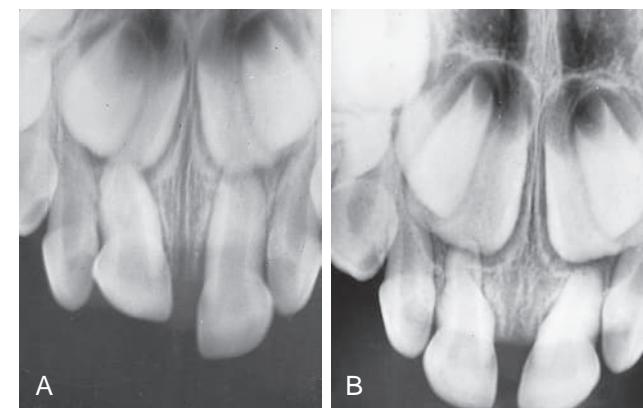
(A) The degree of intrusion of the primary tooth. Damage to the permanent teeth often results from an injury of this type. (B) Radiograph obtained 8 months after the injury shows that the injured tooth has re-erupted. The pulp has retained its vitality, although there is evidence of partial obliteration of the pulp canal. External root resorption has occurred on the adjacent central incisor.
